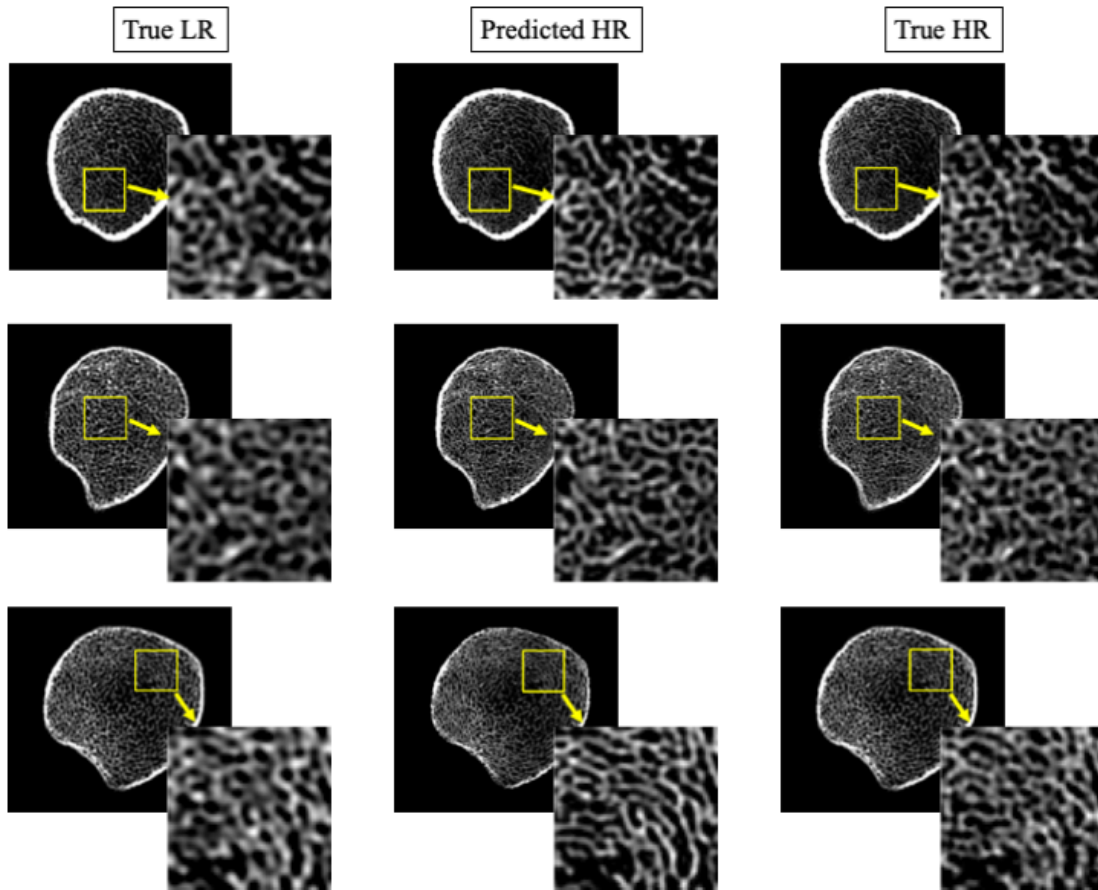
Reconstructed HR images from LR CT scans using GAN-CIRCLE and comparison with true HR scan data. Each row presents matching original and reconstructed axial image slices from a human distal tibia dataset. Left-to-right columns: a 2-D image slice from a LR CT scan on a Siemens FLASH scanner (left); predicted HR image slice from the LR CT data (middle); and true HR image slice from post-registered Siemens FORCE scan (right).
